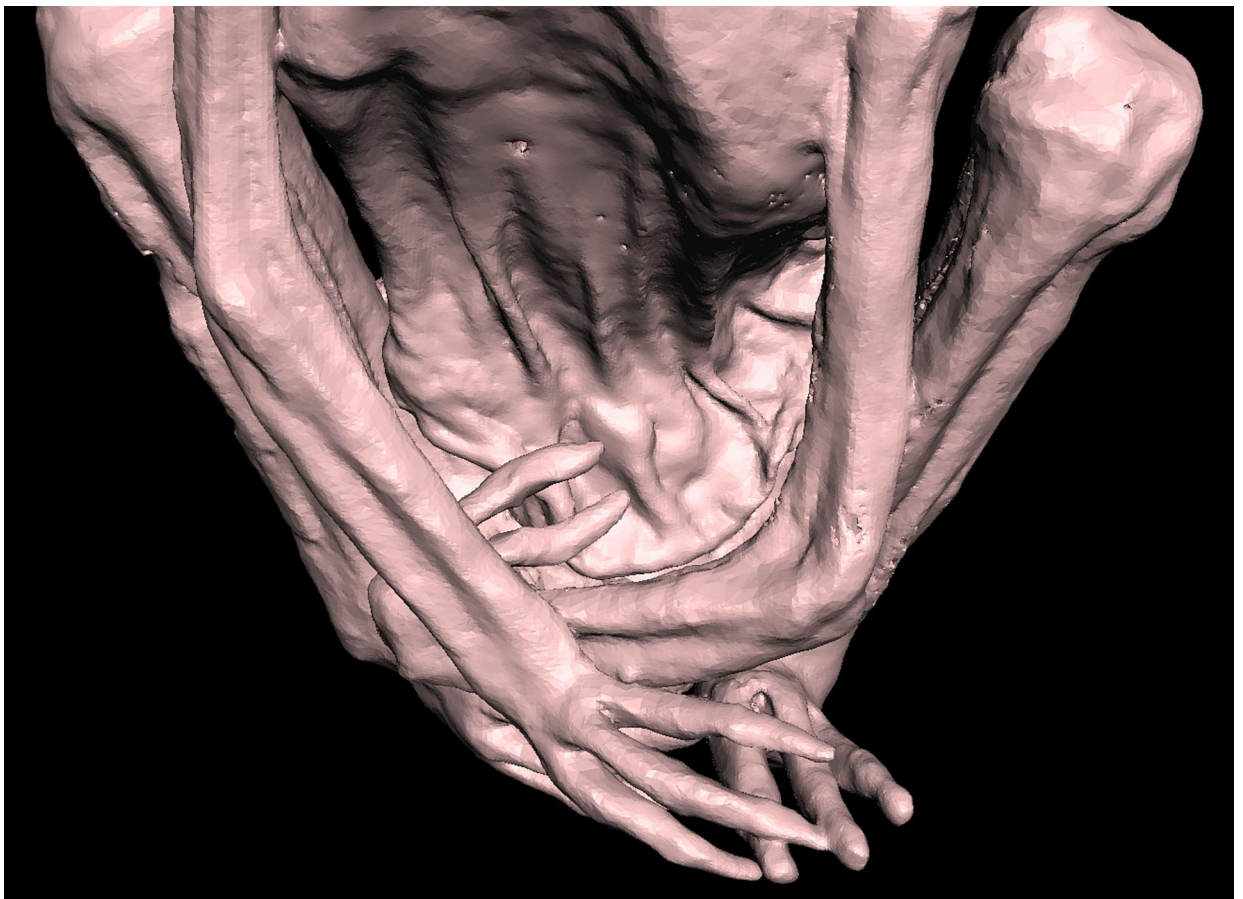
3D CT showing prominent median abdominal fold and absence of navel.
